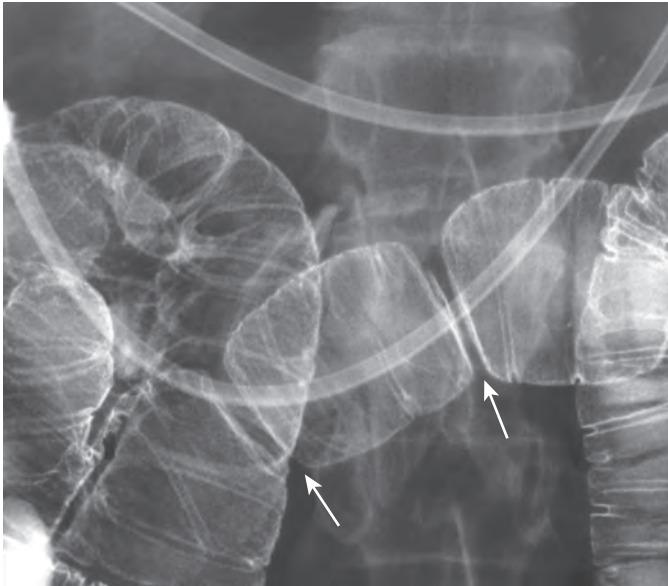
Ringlike strictures related to NSAID use. A spot radiograph from enteroclysis demonstrates two ringlike narrowings (arrows) in the jejunum. (Courtesy Arunas Gasparitis, MD, Chicago.)
